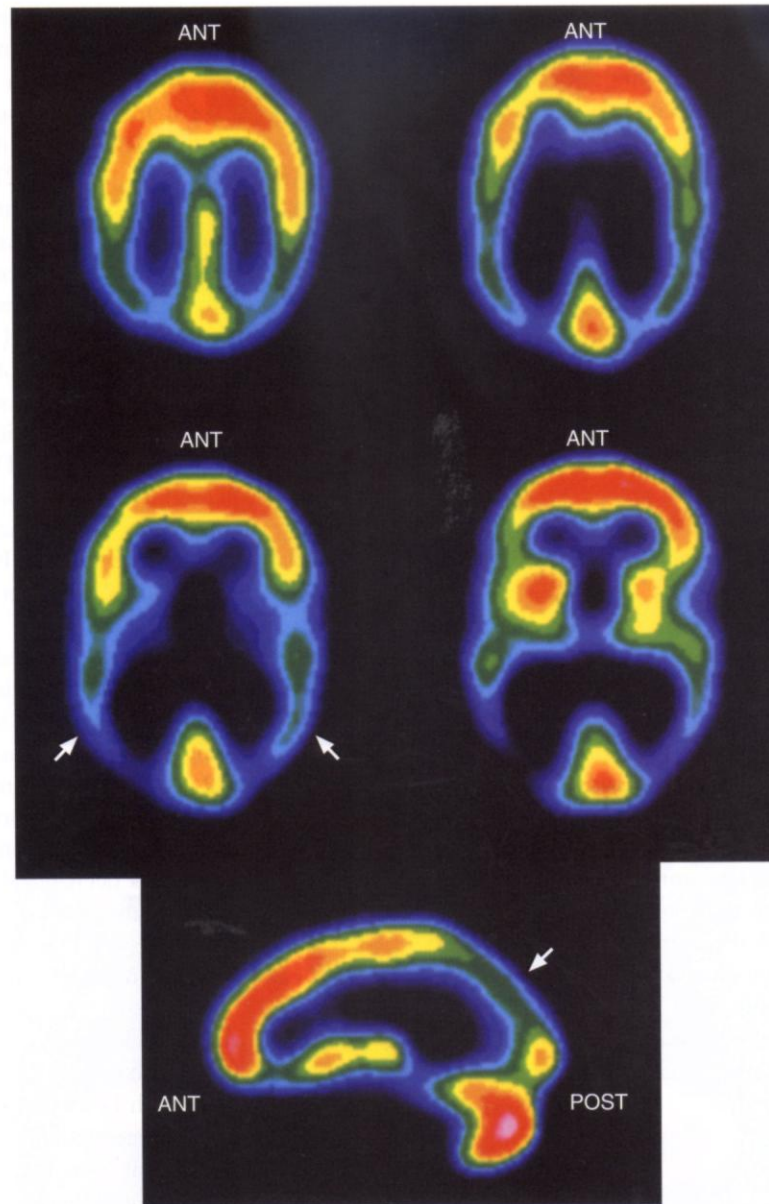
Alzheimer’s dementia. Multiple transaxial and one sagittal image from a ^{18}F -FDG PET scan show symmetrically decreased metabolic activity in the posterior tempoparietal regions (*arrows*).
